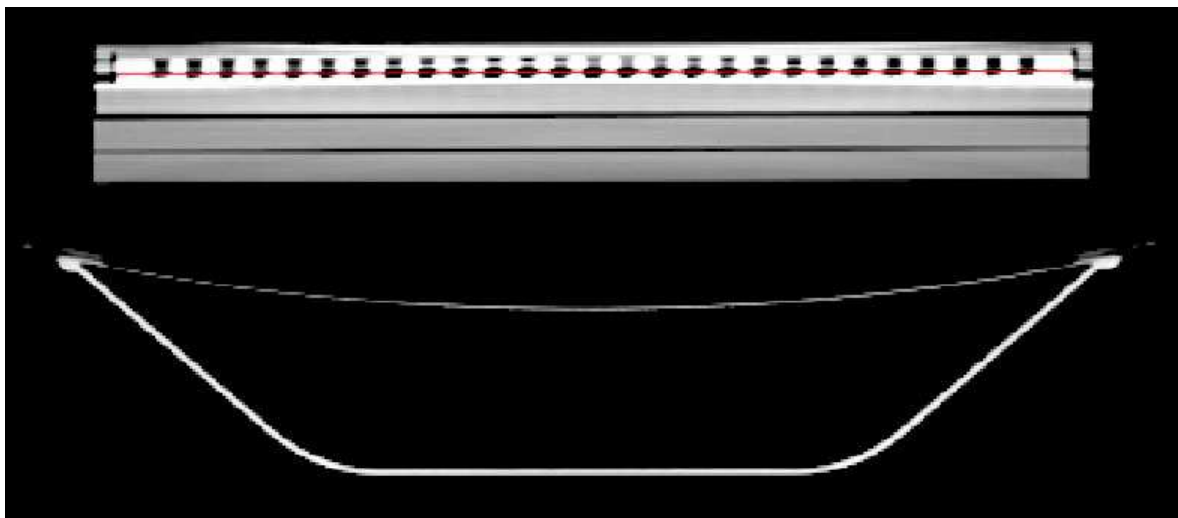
CT-slice in transversal direction of the PTW 729 array
